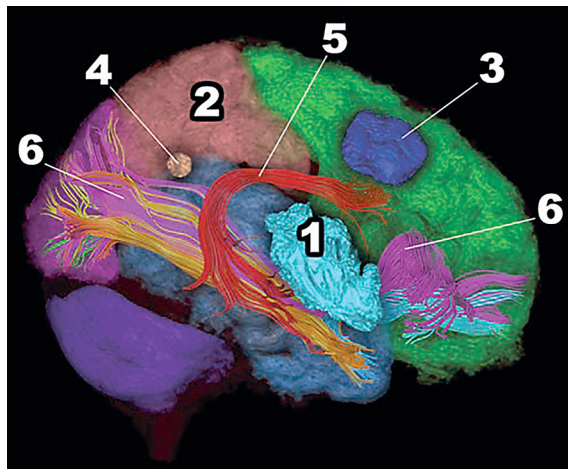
3D reconstruction based on MRI data. Numbers indicate the brain areas responsible for producing symptoms during seizures in the patient: 1) insula (turquoise) and frontotemporal operculum – oroalimentary automatisms; 2) parietal lobe – version of the head (parietal gaze center); 3) frontal gaze center – version of the head and eyes; 4) tumor; 5) arcuate fasciculus; 6) superior longitudinal fasciculus.
